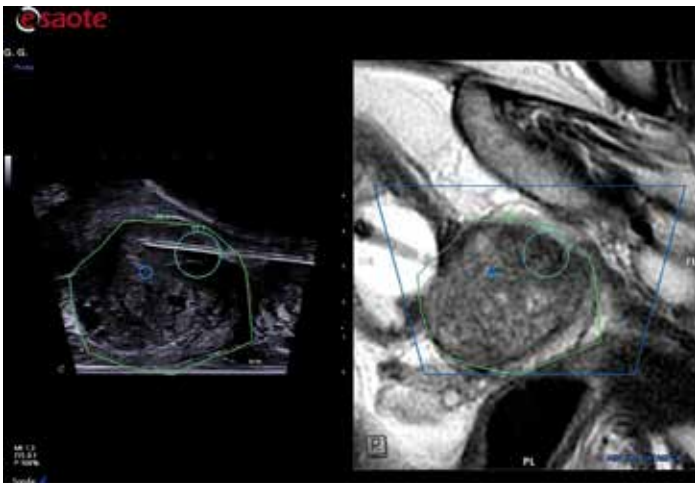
Example of TP biopsy - After the samples are taken from the target area, the doctor progresses to a systematic biopsy of the gland (around 12 samples) to cover any lesions not visible on the MRI.
